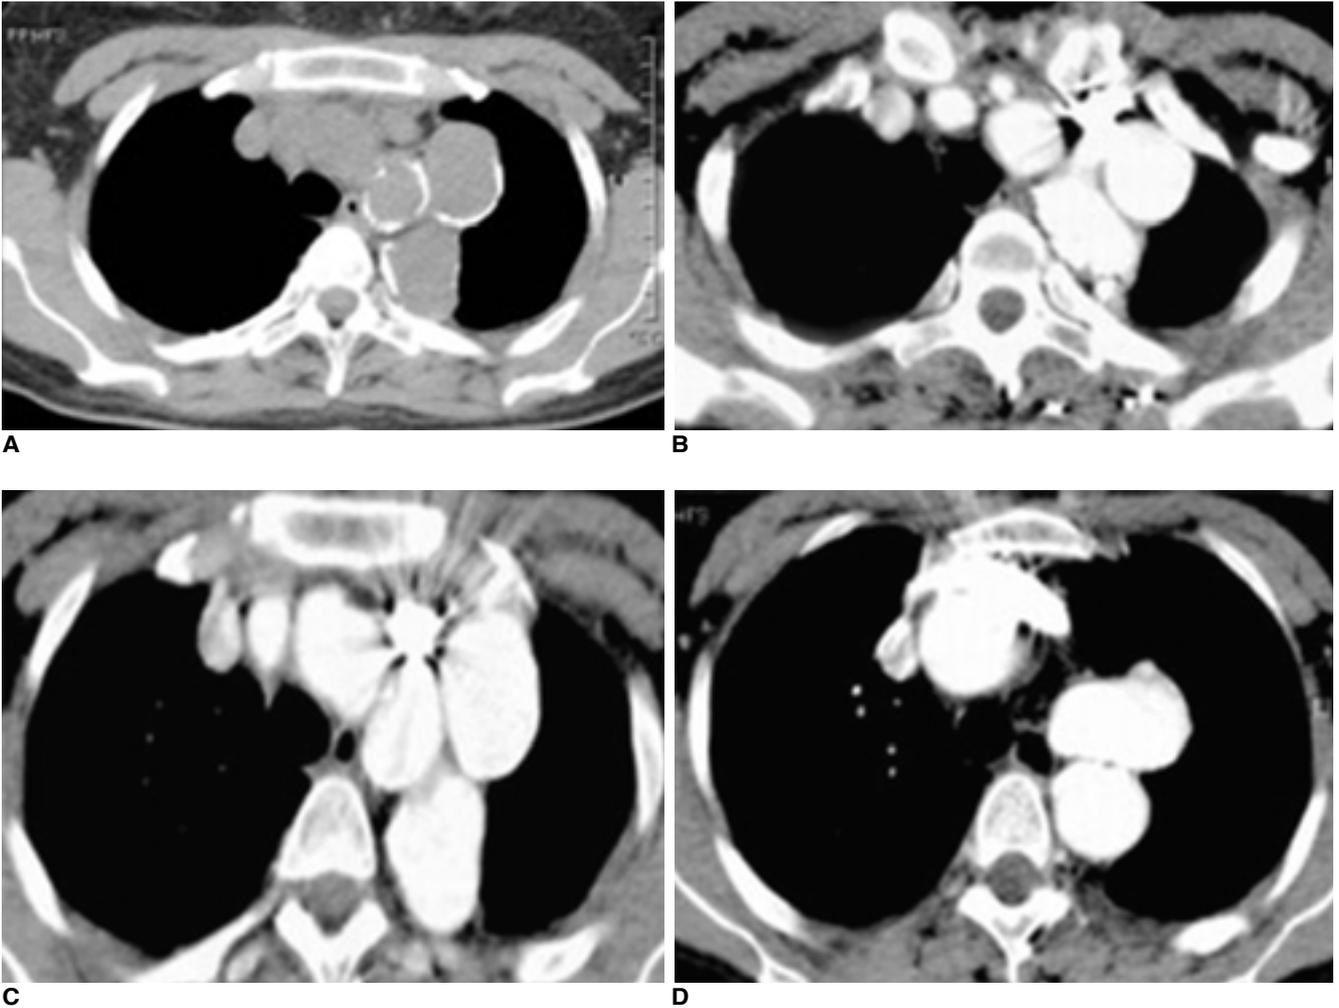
On axial CT scan, mural calcification is noted in aortic arch (A). Corkscrew shaped aortic arch is noted (B, C, D). Some aneurysmal change is combined in this tortuous aortic arch. The apex of the tortuous aortic arch is above the level of the clavicle.
